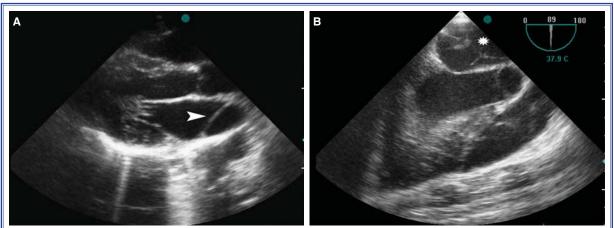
(A) Cor triatriatum sinistrum dividing the left atrium into two compartments in parasternal long-axis view (arrow). (B) Transesophageal echocardiography showing the membrane with fenestrations (star).
